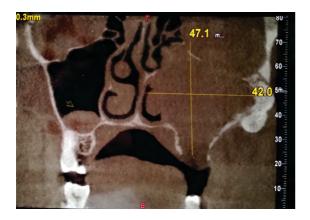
CBCT Images (a) coronal view, (b) 3D Reconstruction view
